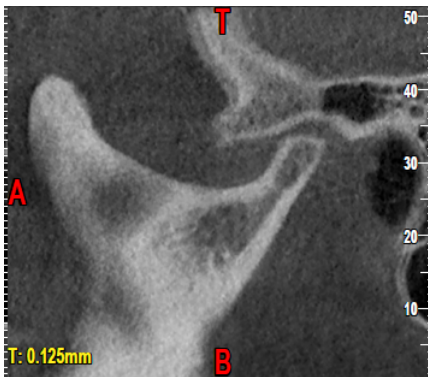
Sagittal view of CBCT revealing flattening of condyle
